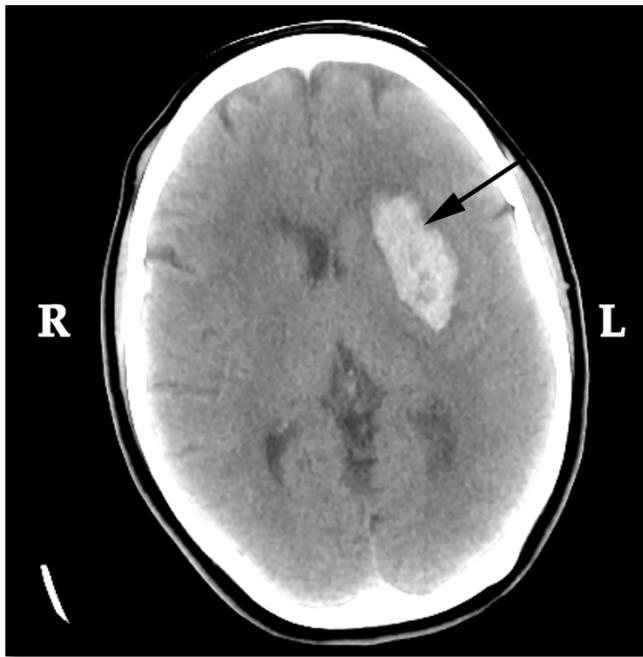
Stroke. Cerebral CT-SCAN showing a parenchymal hemorrhage (arrow) in the left capsule-ganglion that compresses the frontal horn of the lateral left ventricle.
